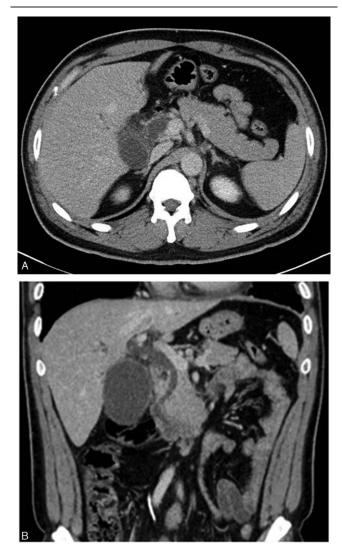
Contrast-enhanced computed tomography scan demonstrated mild pancreatic edema (A) and diffuse biliary tree dilatation and distension of gallbladder without evidence of stone (B).
